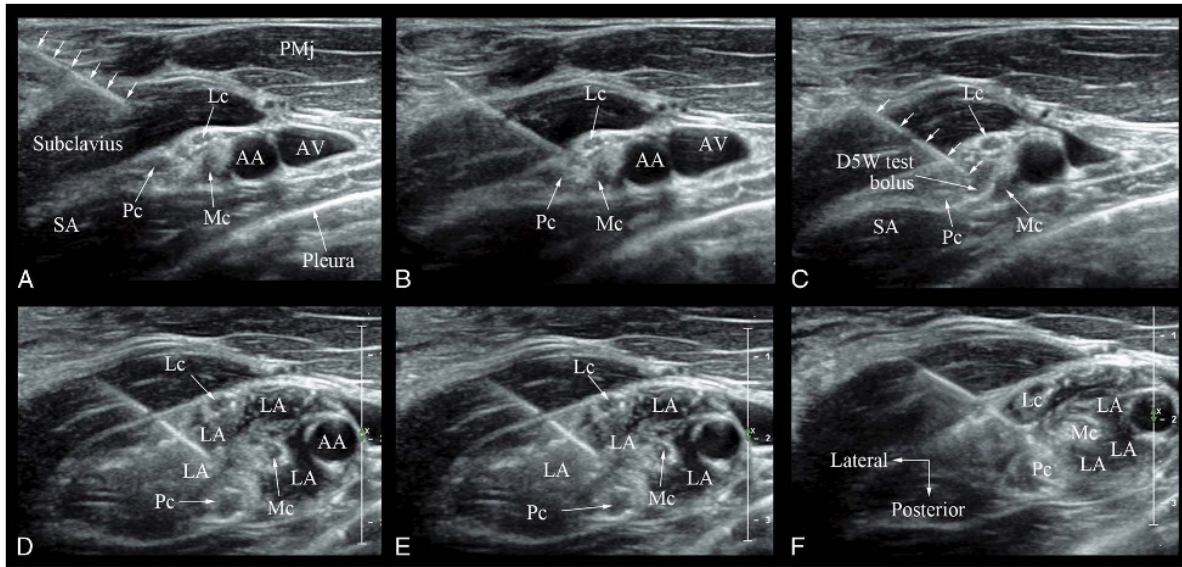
A sequence of transverse sonograms captured during an ultrasound-guided costoclavicular BPB. Note that the orientation label has been placed over Figure 6F. A, The block needle is inserted in-plane from a lateral to medial direction; the needle tip is being advanced through the gap between the lateral and medial cord (B), with the needle tip positioned at the center of the nerve cluster (C). D-F, Note the effect of the test bolus injection of 1 to 2 mL dextrose 5% during and after LA injection .
